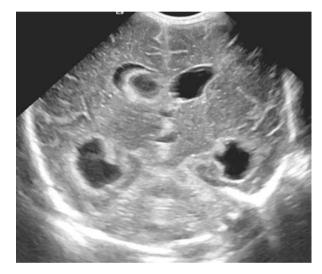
Grade II IVH. This coronal view of a head ultrasound demonstrates moderate IVH occupying the lateral and third ventricles without ventricular dilation, consistent with Grade II IVH. Subsequent imaging on this same patient demonstrated resolution of the IVH without ventricular enlargement
